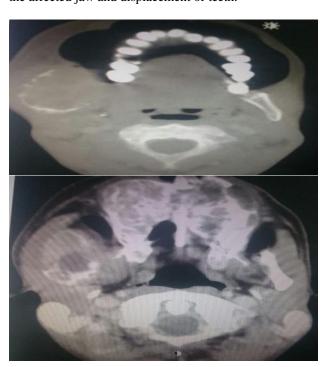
CGCTG; CT scan axial images shows multiloculated, expansile lytic lesions involving mandible, maxilla, hard palate with characteristics ground glass haze.
